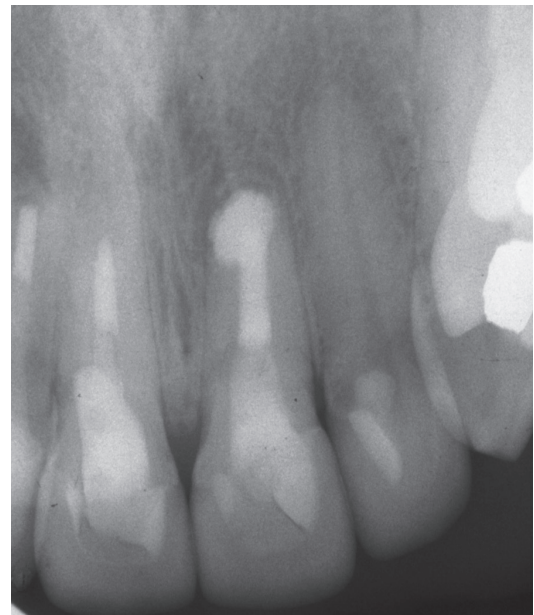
Four-year follow-up radiograph in which healing of the apical lesion is evident.
